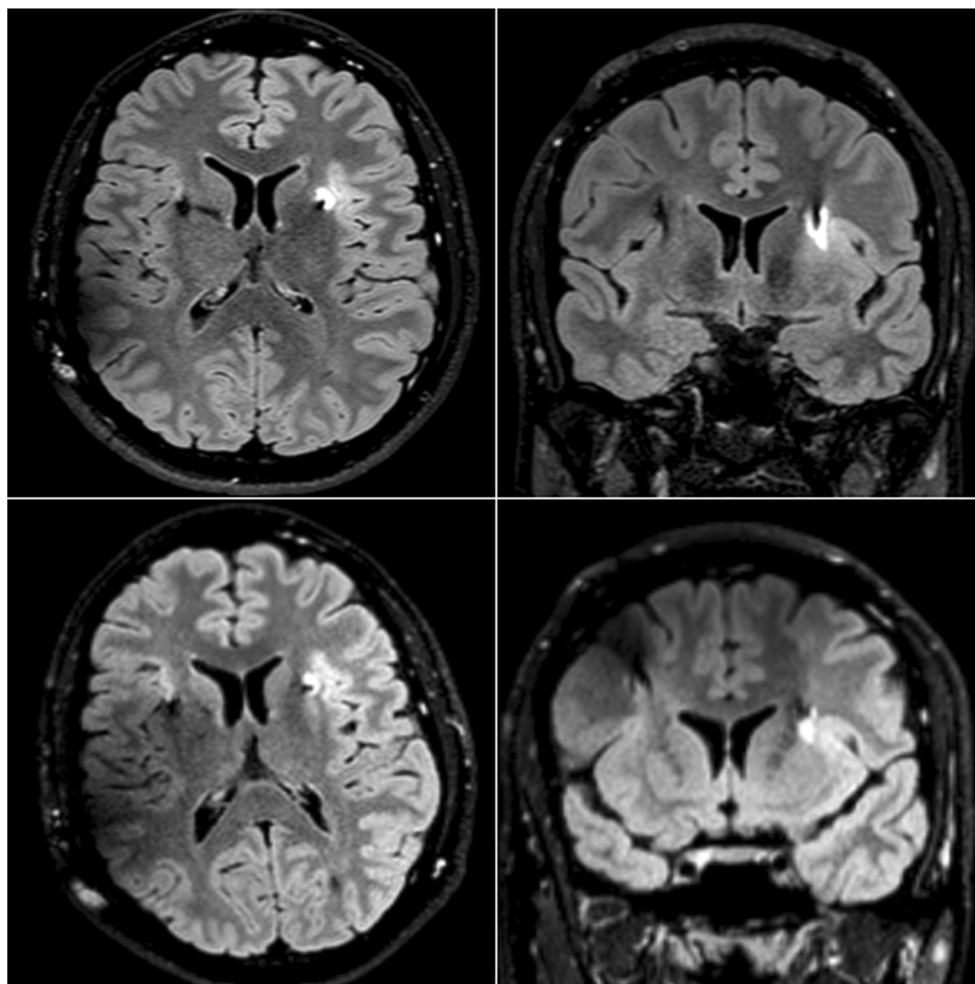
Left peri-lead edema. Top: fluid attenuation inversion recovery (FLAIR) images in axial (left) and coronal (right) sections. Bottom: same sections 3 months later
